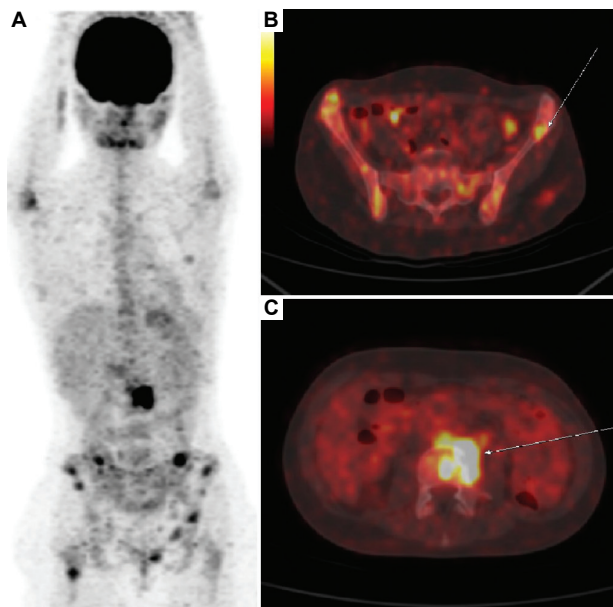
Hypermetabolic uptake is seen in the right humeral head, lumbar spine (L2 and L3), iliac wings, and right femoral diaphysis corresponding to brown tumors. Multiple hypermetabolic lytic foci in both iliac wings and a focus in the lumbar spine at L2 are suggestive of spondylodiscitis. (A) 3D Maximum Intensity Projection (MIP) image showing hypermetabolic foci in the right humeral head, the lumbar spine at the level of L2 and L3, the iliac wings, and the upper end of the right femoral diaphysis, corresponding to morphological images of brown tumors. (B) PET/CT fusion image of the pelvis in the sagittal section showing multiple hypermetabolic lytic lacunar foci in both iliac wings, corresponding to brown tumors. (C) PET/CT fusion image of the lumbar spine at the level of L2 in the sagittal section highlighting a hypermetabolic focus in the body of L2 associated with diffuse and heterogeneous hypermetabolism of the lateral wall of L2 and adjacent areas suggestive of spondylodiscitis focus.
